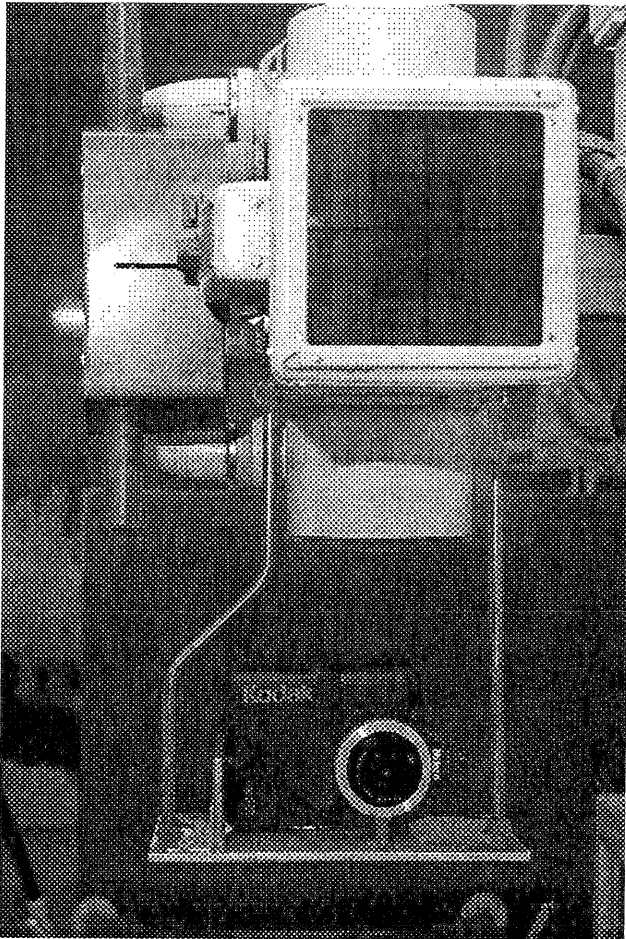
DCS200 camera mount fixed to X-ray tube.
